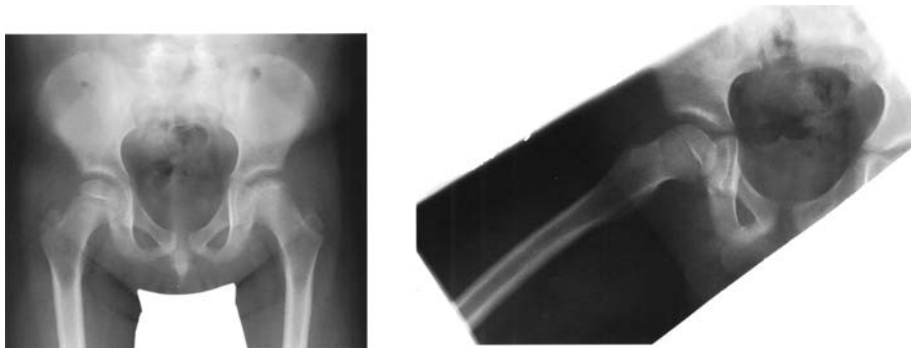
Radiograph of pelvis demonstrating changes of Legg-Calvé-Perthes disease. Note the sclerotic, flattened, and fragmented right femoral head.
